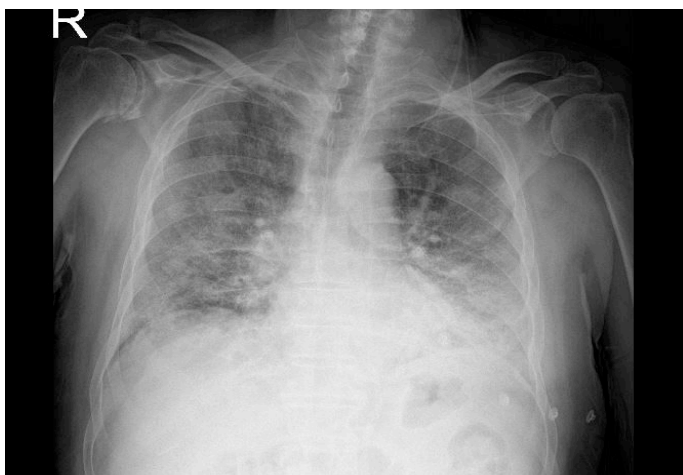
Chest X-ray (CXR) of a 75 years old male COVID-19 patient who admitted to intensive care unit. CXR demonstrates bilateral patchy ground glass opacities with accompanying consolidation at left lower zone. Radiographic assessment of lung edema score was assigned as 20 and 21 for Observer 1 and observer 2, respectively.
